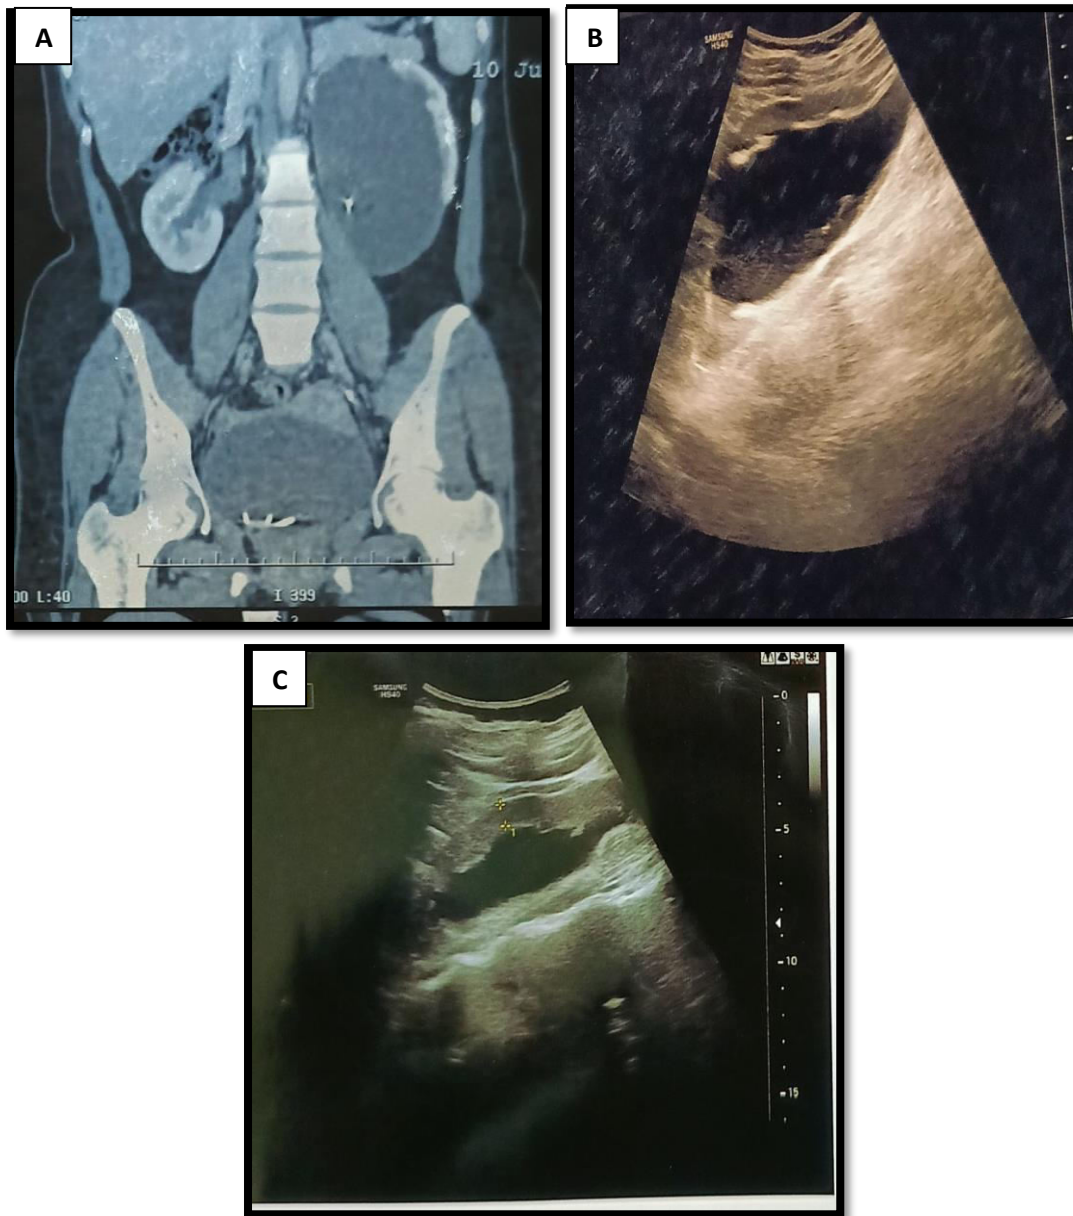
[A] Contrast enhanced CT showing gross hydronephrosis of left kidney with non dependent UPJ, [B] Preoperative ultrasound showing hugely dilated renal pelvis and reduced cortical thickness, [C] Postoperative ultrasound showing improvement in APD pelvis and CT
